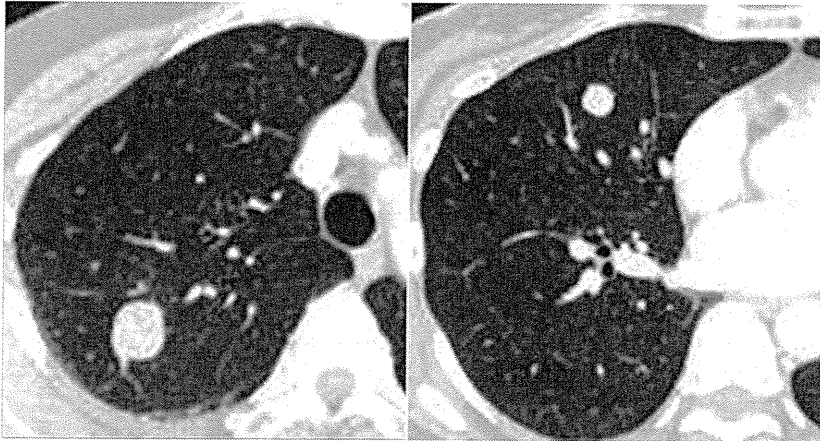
Computed tomography demonstrated round-shaped masses with sharp borders in the right S2 (2.2 cm in diameter) and S4 (1.1 cm in diameter) regions
